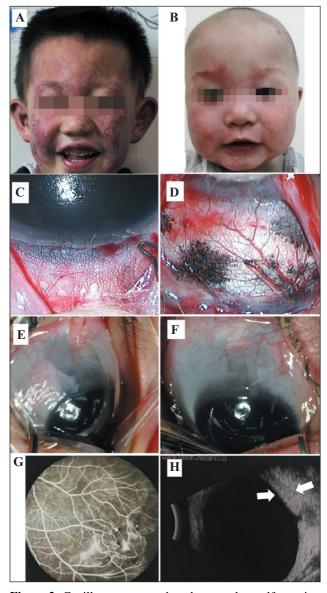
Capillary naevus and ocular vascular malformation in patients with phacomatosis pigmentovascularis. Facial naevus flammeus is darker in a patient with glaucoma (A) than a patient without glaucoma (B). C, D) Dilated episcleral vessels with increased density present a reticulate appearance with episcleral melanosis. E, F) Dark and total perilimbal episcleral hyperpigmentation are shown in the eyes. G) Fundus fluorescein angiography shows peripheral retinal vascular leakage, venous shunts and tortuous capillaries. H) Choroidal haemangioma (white arrow) demonstrated by B-scan ultrasonography.
